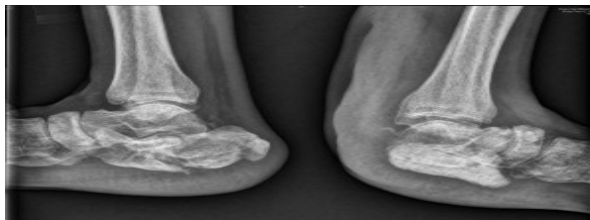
Xray showing follow up of bilateral calcaneum fractures at 3 months
